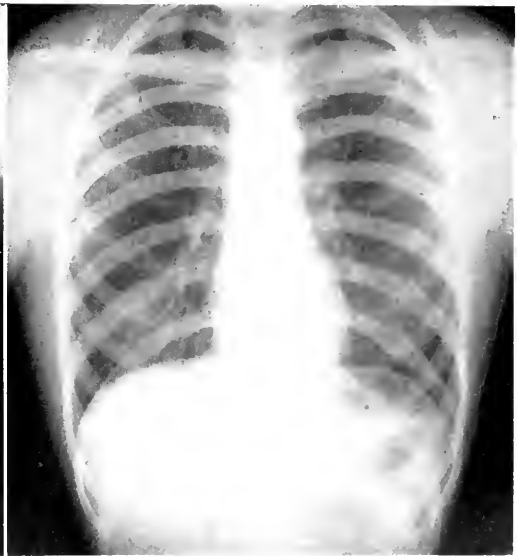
Shoulders lowered. Clavicular shadow horizontal and visibility of the apical field increased. The normal position of the anatomical landmarks about the apex is approximately maintained, thus facilitating the comparative study of physical and x-ray findings.
